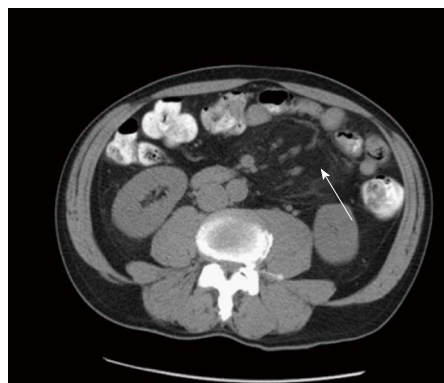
Inflammation of the small bowel adipose tissue formed as a pseudotumor in the left abdomen in the transverse abdominal computed tomography (white arrow).
